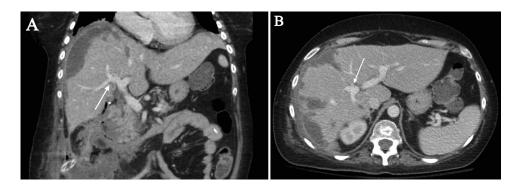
Coronal (A) and axial (B) contrast-enhanced CT images obtained 32 days after subcapsular hematoma evacuation demonstrate regions of persistent wedge-shaped nonenhancement in the periphery of the right hepatic lobe, consistent with peripheral hepatic infarcts. Note that the caliber of the right portal vein has been restored to normal (arrows) following hematoma evacuation and resolution of mass effect upon the liver.
